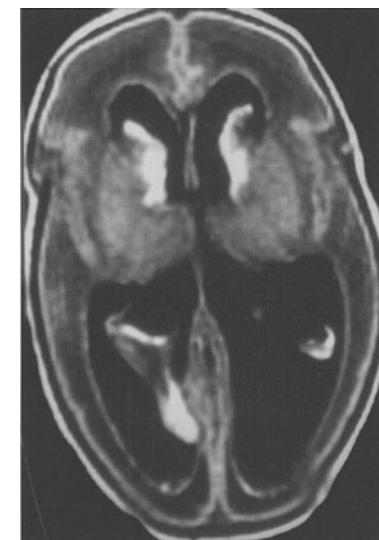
MRI showing intraventricular hemorrhage and hydrocephalus
